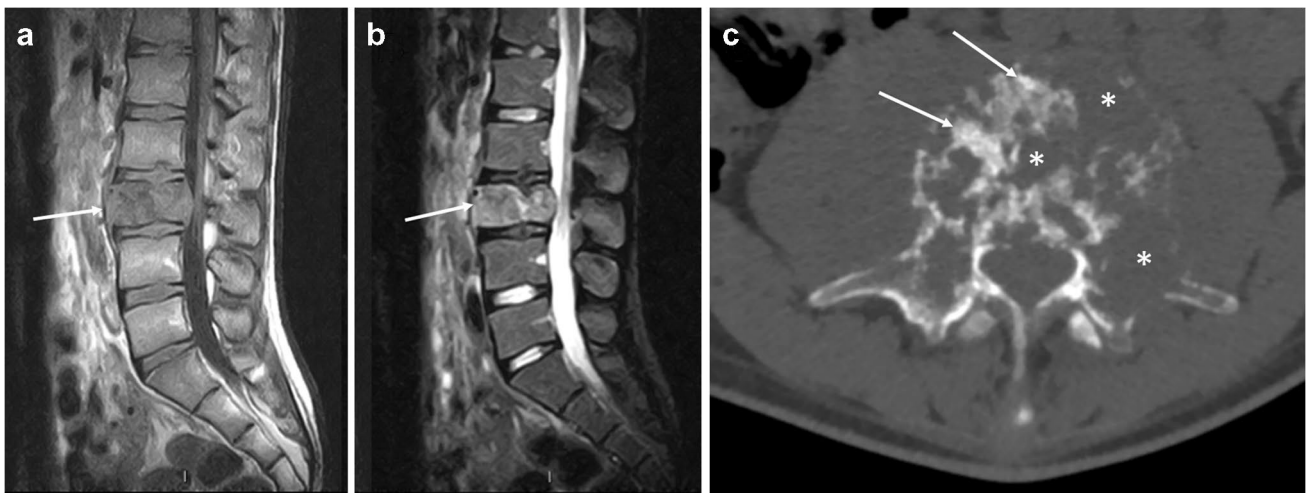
Images of a 16-year-old boy with severe low-back pain which started 3 months before, non-responsive to analgesic drugs. Intermittent fever was also present. a, b Sagittal T1 (a) and T2 (b) magnetic resonance imaging sagittal T1w of the spine reveal a pathological fracture (*arrows*) with an intracanal protrusion of the posterior wall of the vertebral body. c Axial spinal computed
